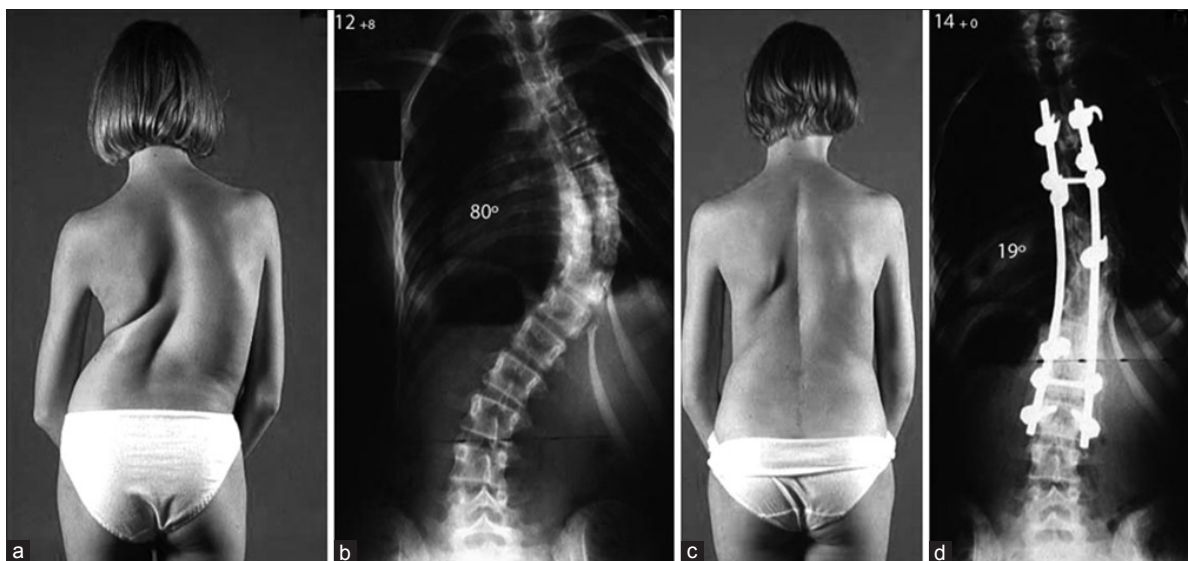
(a,b) Clinical photograph and spinal radiograph of a female adolescent patient show a severe right thoracic scoliosis producing elevation of the right shoulder, prominence of the scapula and ribs adjacent to the convexity of the curve, as well as thoracic translocation to the right and waistline asymmetry with prominence of the left side of the pelvis. (c, d) a posterior spinal fusion with the use of hybrid hook/screw/rod instrumentation and autologous iliac crest bone graft achieved a balanced spine in the coronal plane with level shoulders and symmetrical waist line
